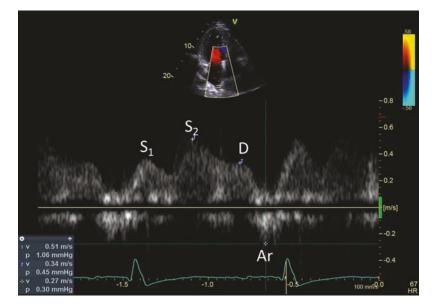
Shown is the pulmonary vein Doppler from the apical view; four measurements are commonly obtained from the pulmonary venous inflow signal including peak systolic velocity (S), peak diastolic velocity (D), peak atrial reversal velocity (Ar), and the duration of Ar; there are two systolic velocities that can be measured (S1 and S2); S1 is a reflection of left atrial relaxation; S2 should be measured and used in comparisons with D
